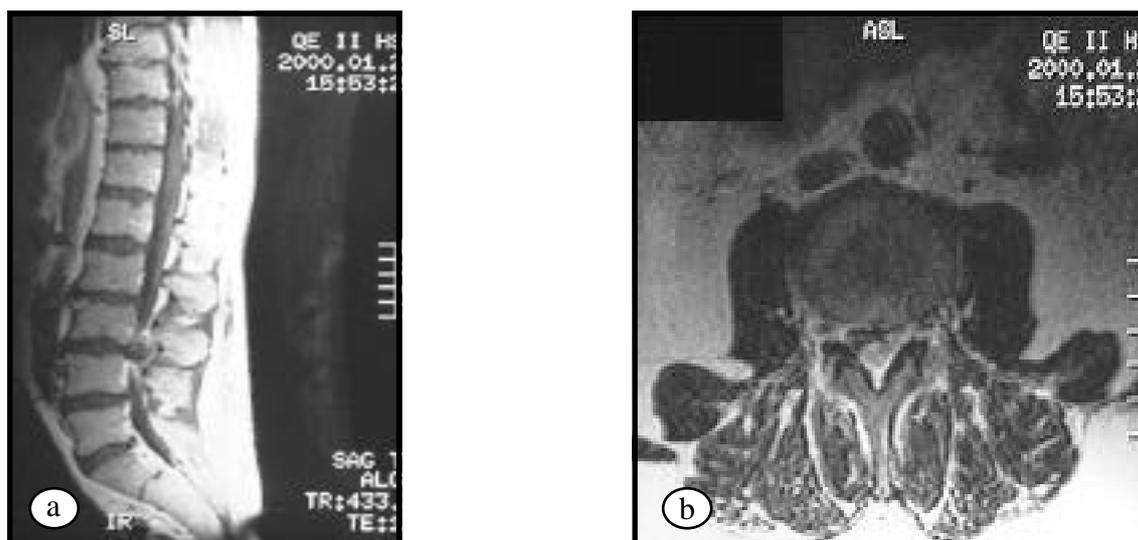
(a) Sagittal and (b) Axial magnetic resonance imaging of the lumbosacral spine showing a large lumbar 3-4 disc herniation.
